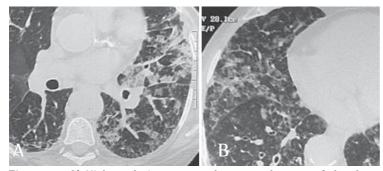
A) High-resolution computed tomography scan of the chest showing a mosaic pattern of attenuation, predominantly in the lower lobes; B) High-resolution computed tomography scan of the chest showing alveolar infiltrate, predominantly in the lung bases, and areas of mosaic pattern of attenuation
